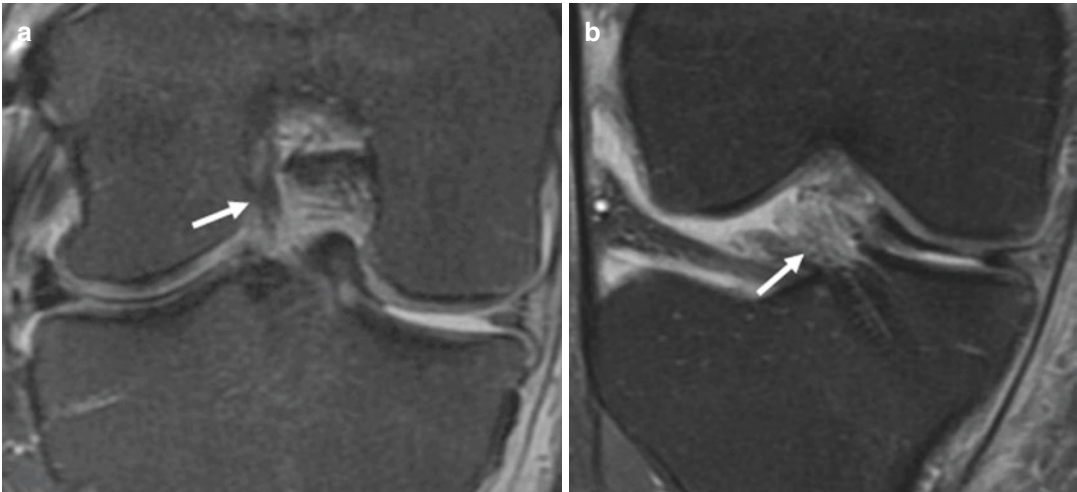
(a) Coronal T2-weighted fat-suppressed images of the right knee of a 16-year-old female 1 year after ACL reconstruction shows normal-appearing graft fibers proximally (*arrow*). (b) However, a more anterior
